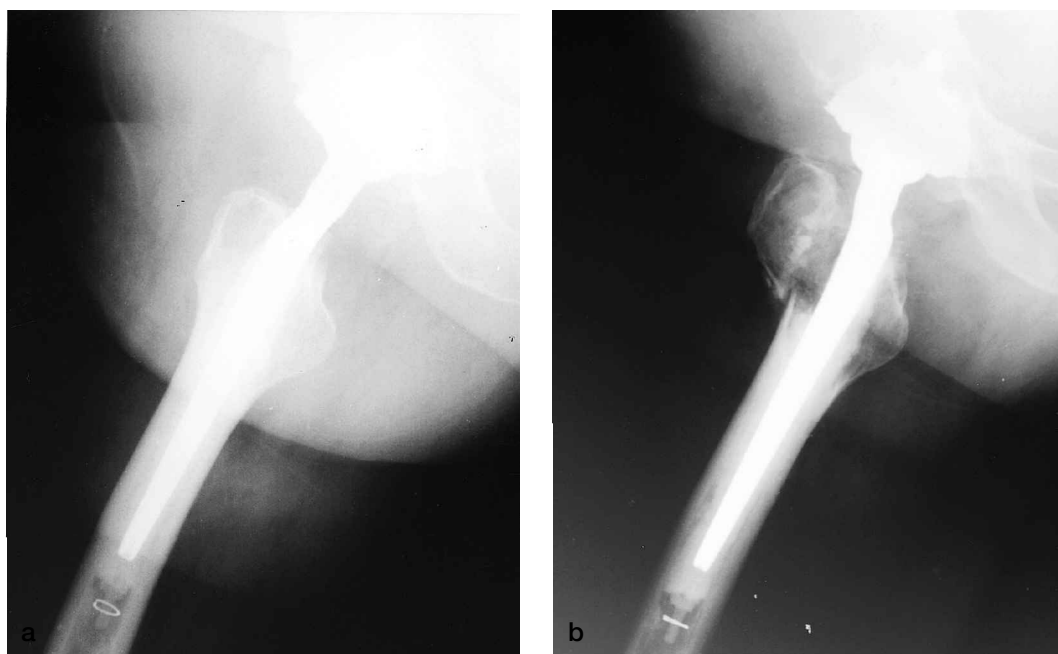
Radiographs showing conversion of a noncemented Thompson prosthesis to total hip arthroplasty. a. Postoperative radiographs—no fracture of the greater trochanter can be seen. b. Radiographs after 3 months—a nondisplaced fracture of the greater trochanter is seen.
